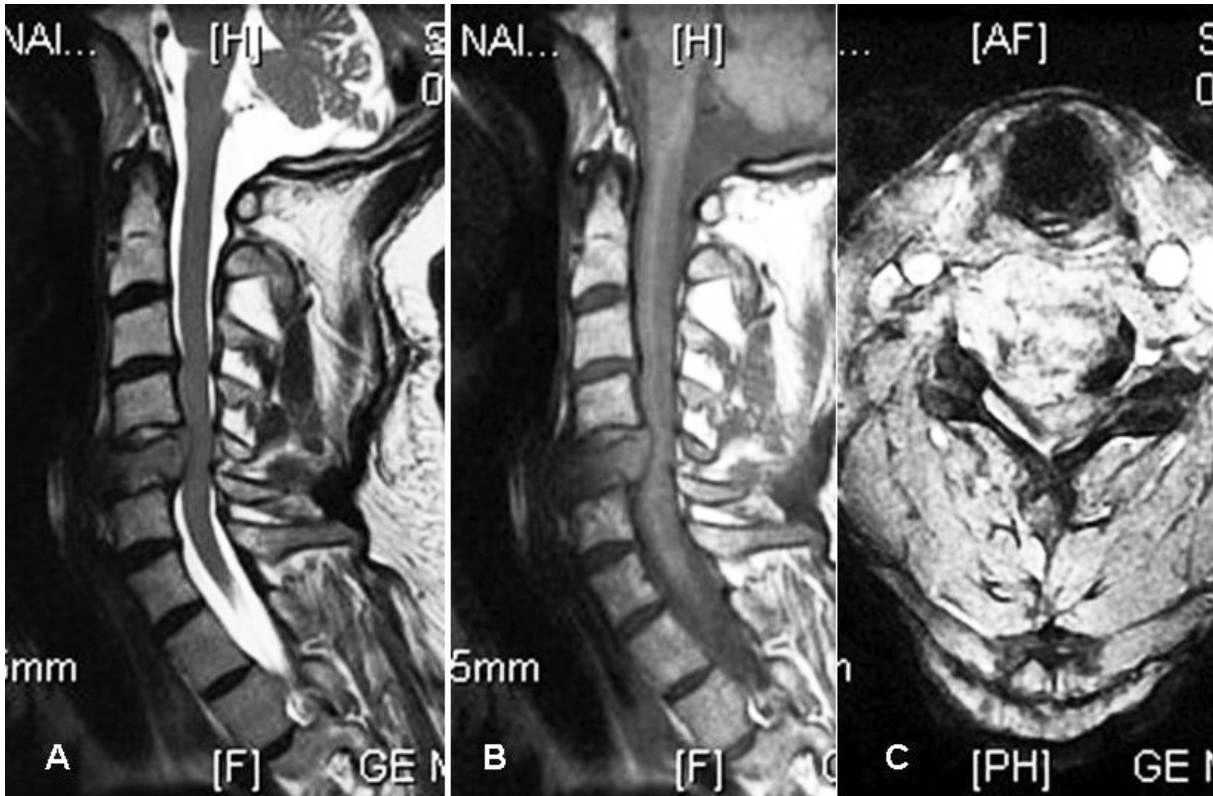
Sagittal T2-weighted (A), sagittal T1-weighted, and axial T2-weighted MRIs revealed spinal cord compression and prevertebral extension of the lesion.
